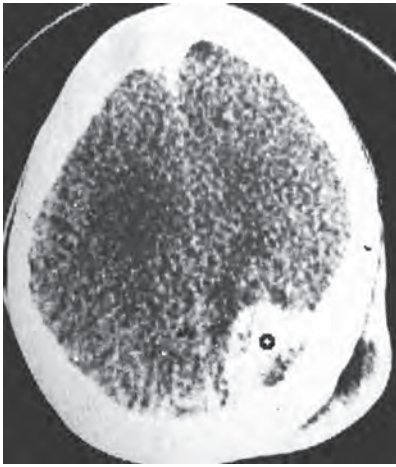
CT scan showing a right occipital tuberculoma which involved the bone and presented as a subgaleal swelling
